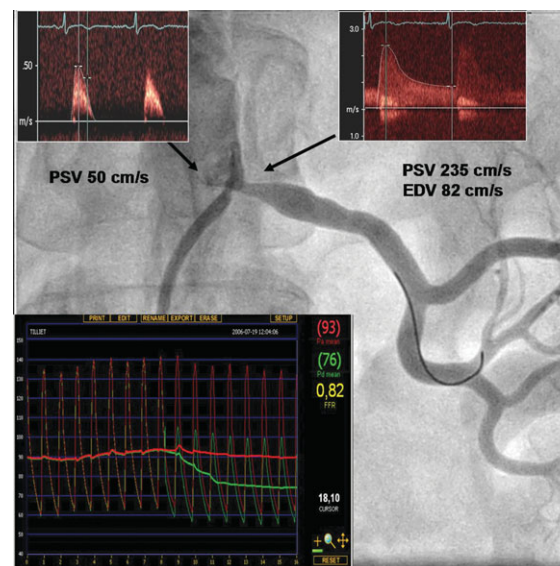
Representative example of angiography, ultrasound measurements, and trans-stenotic pressure gradient measurements in left renal artery stenosis. Inserts in the upper part of the figure depict ultrasound data in the aorta (left) and at the level of the stenosis. On the insert, in the lower part of the figure, the invasive pressure gradient measurements are shown. In this particular case, a ratio between distal renal pressure (P_d) and aortic pressure (P_a) of 0.82 is measured, indicating a haemodynamically significant stenosis
